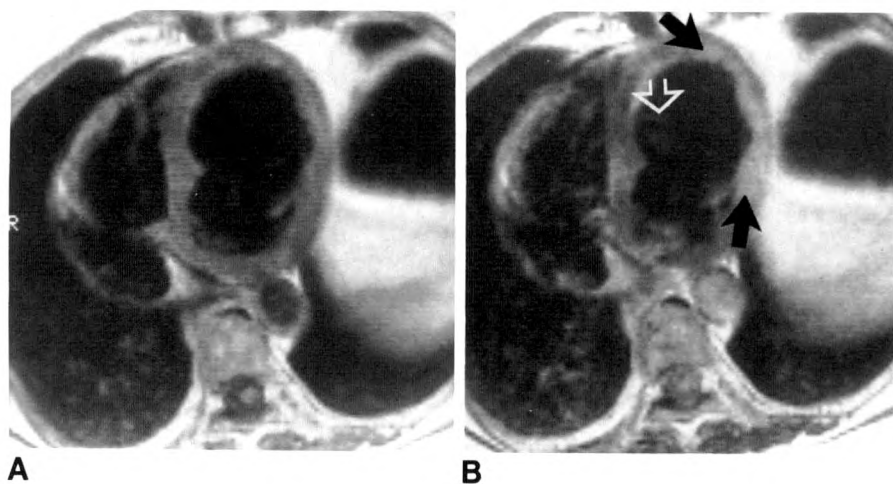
Spin-echo MR images of patient with acute anterolateral wall myocardial infarction. Images are from patient examined after completion of study.
